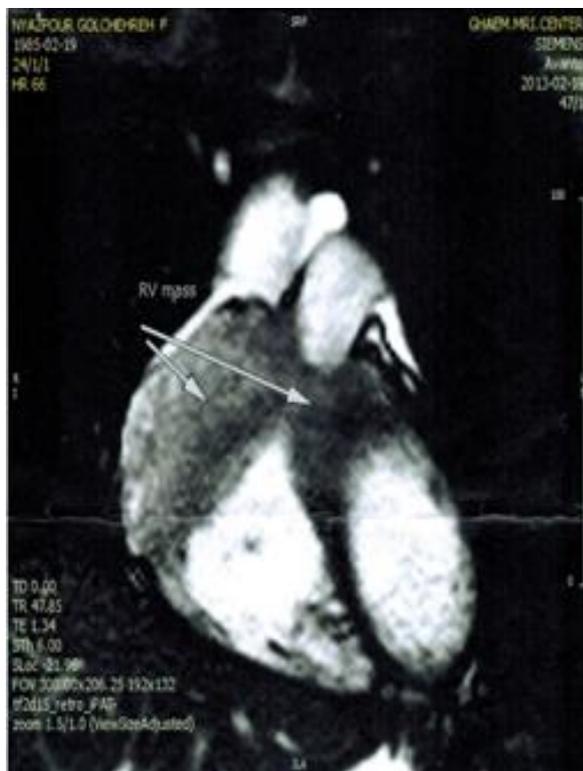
Cardiac MRI (T2) Of Right Ventricle
